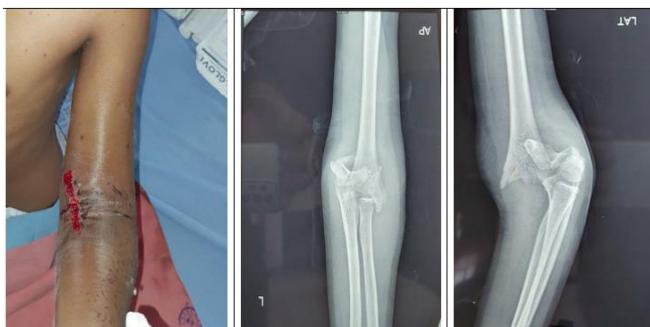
Clinical image & Anteroposterior & lateral x-rays views showing supra-condylar fracture.
